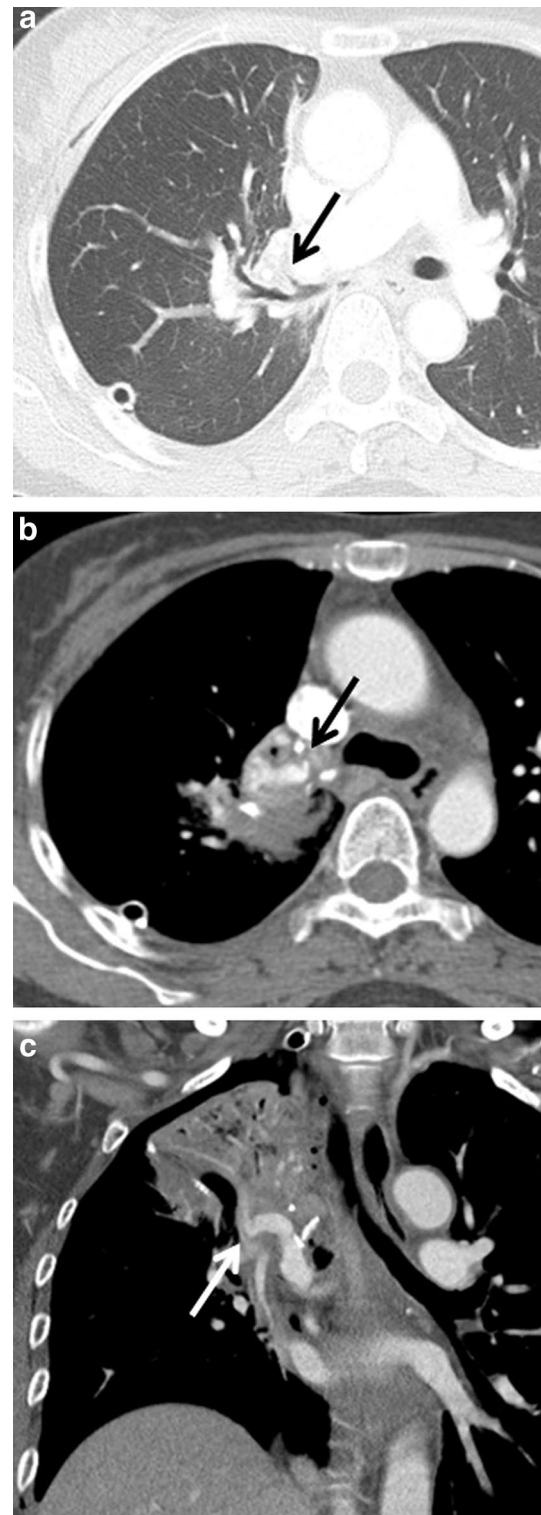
Right middle lobe torsion in a 57-year-old woman treated with right upper lobectomy for adenocarcinoma. a Lung window setting axial CT image reveals occlusion of the right middle lobar bronchus (arrow). b, c Mediastinal window setting axial CT and coronal CT images show an abnormally rotated right middle lobar pulmonary artery (arrows). Right middle lobe was twisted 180 degrees on video-assisted thoracoscopic surgery
